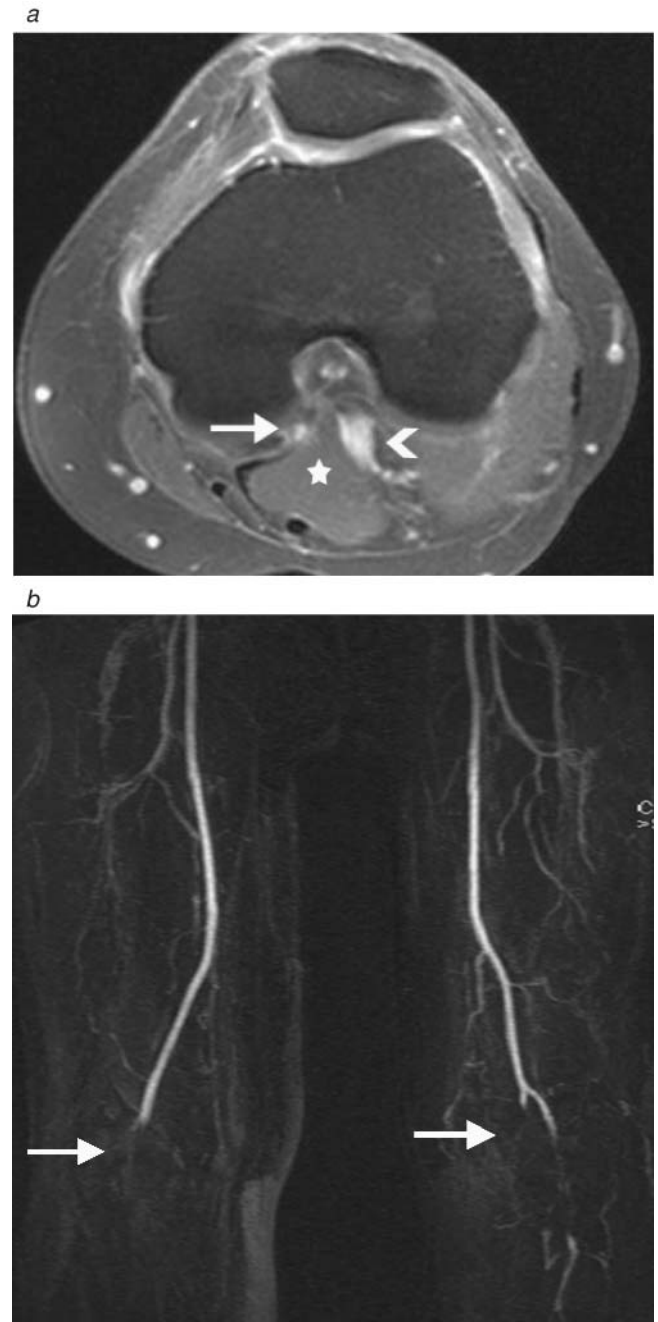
A 39-year-old male athlete with bilateral claudication when running. (a) An axial contrast-enhanced magnetic resonance image at the left popliteal fossa demonstrates the popliteal artery (arrow) separated from the popliteal vein (arrowhead) by a muscular band (star), which is from the medial head of the gastrocnemius muscle. This finding is consistent with popliteal arterial entrapment syndrome. (b) Coronal maximum-intensity projection from a time-resolved magnetic resonance angiogram with the patient in plantar flexion demonstrates occlusion of both right and left popliteal arteries (arrows) with some reconstitution distally. This is consistent with bilateral popliteal arterial entrapment.
